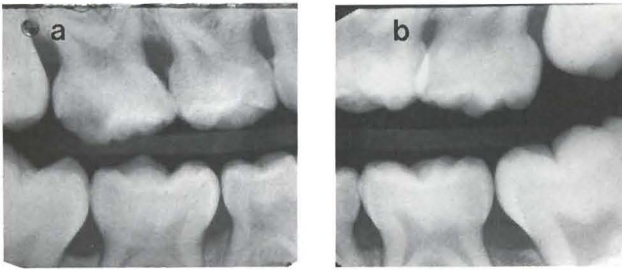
a,b. Radiographs of the patient taken at the age of 6.5 years. a: patient's right posterior segment. b: patient's left posterior segment. Alveolar bone resorption is evident around tooth-numbers A, B, and L.
